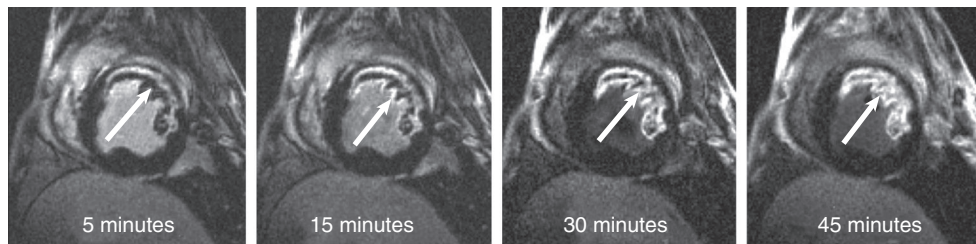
e14 Sequential delayed-enhancement cardiac magnetic resonance images demonstrate a no-reflow zone in an anterior infarction, manifested as a dark region surrounded by hyperenhancing myocardium. Labels refer to the time after administration of gadolinium. Note that the no-reflow zone fills in and becomes smaller over time. (From Higgins CB, de Roos A, editors: Cardiovascular MRI and MRA. Philadelphia, Lippincott Williams & Wilkins, 2003.)
